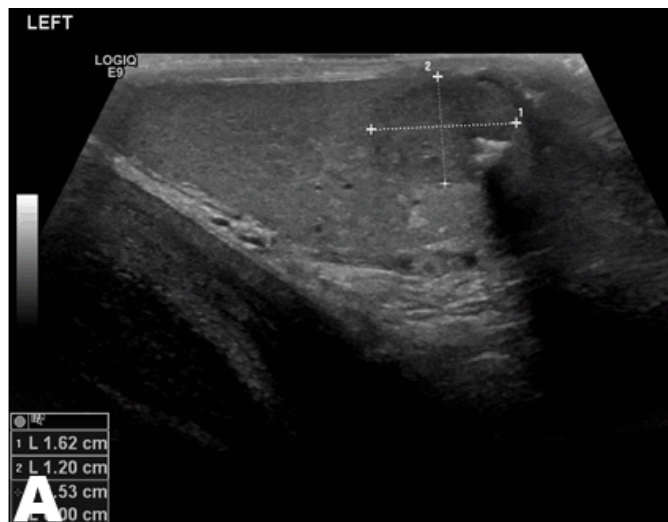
Ultrasound scan left testis, (A) Testicular well-defined solid lesion with calcific area, (B) Internal vascularity of lesion demonstrated.
